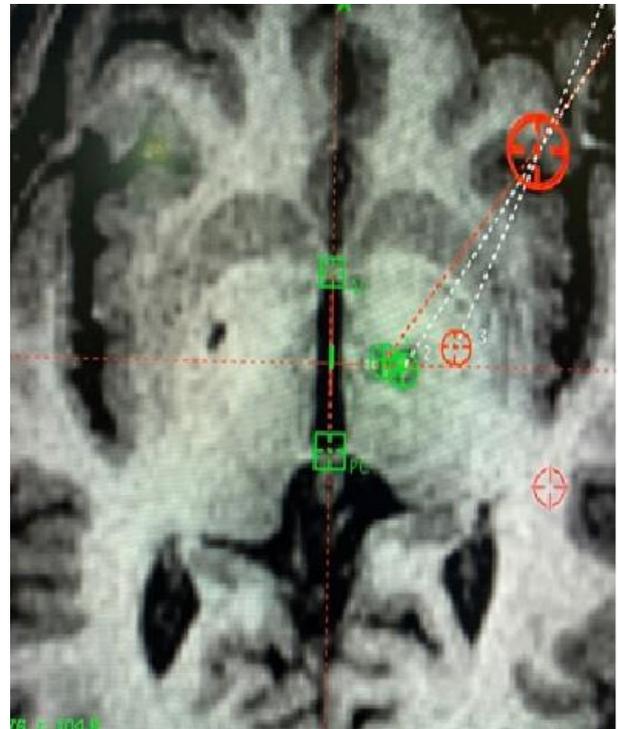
Surgiplan software post-op MRI, showing the precision of targeting with pre-op planned targets in Green and the post-op lesion.
